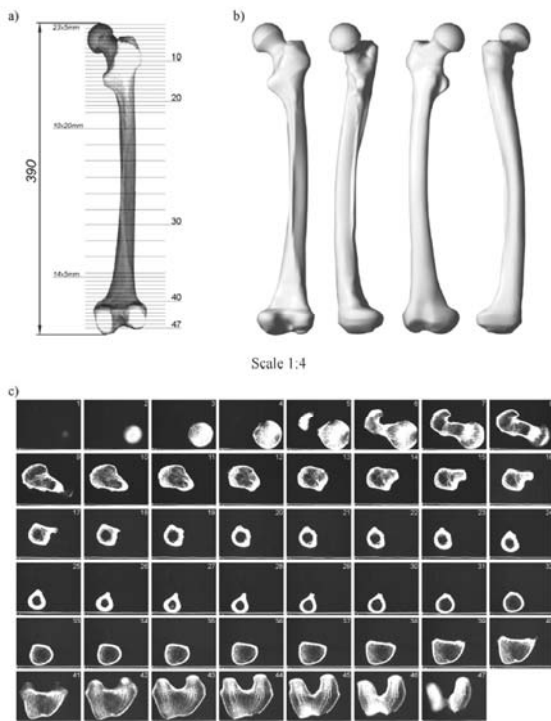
Hip bone geometry transfer using computed tomography: a) bone division procedure; b) transferred geometry; c) tomographic images
